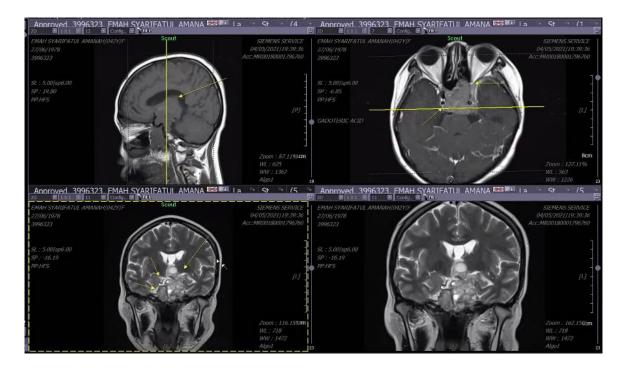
Dynamic pituitary MRI revealed giant recurrence pituitary adenoma after four times surgery and 30 doses of external radiotherapy.
